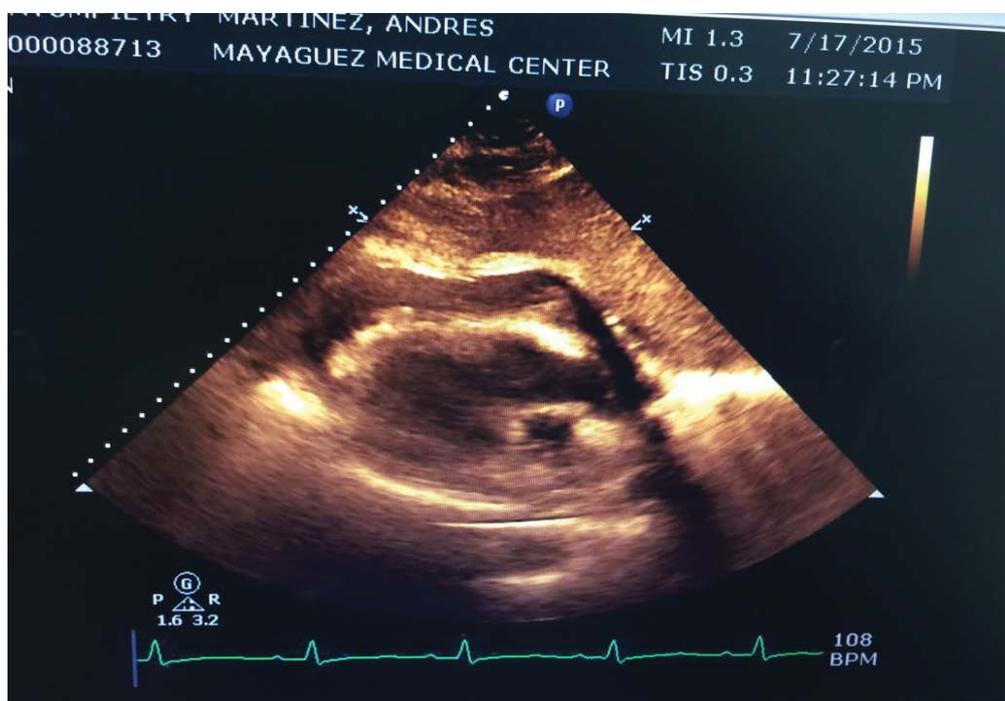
Echocardiography: diffuse global hypokinesia.
